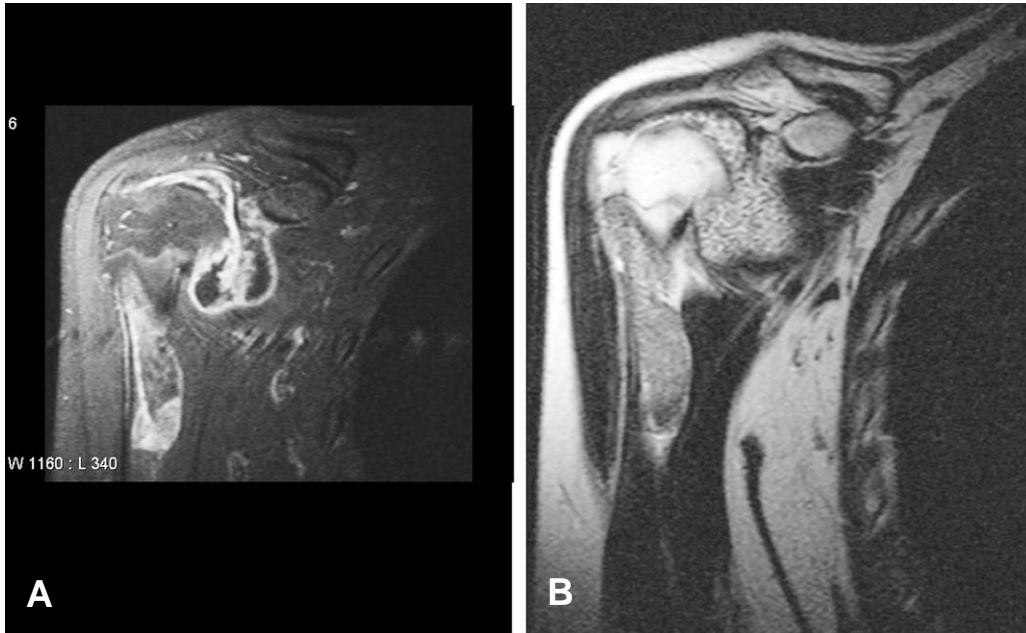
(A) Gadolinium-enhanced, fat-suppressed T1-weighted MR oblique coronal image and (B) T2-weighted oblique coronal image depict multiple tiny loose bodies within the glenohumeral joint, subcoracoid bursa and bicipital groove with synovial proliferation and enhancement.
